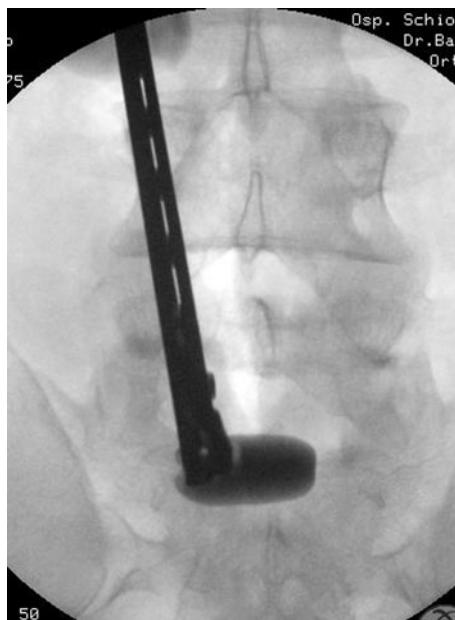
Intraoperative X-ray control during positioning of NUBACTM trial into the disc space L5-S1
